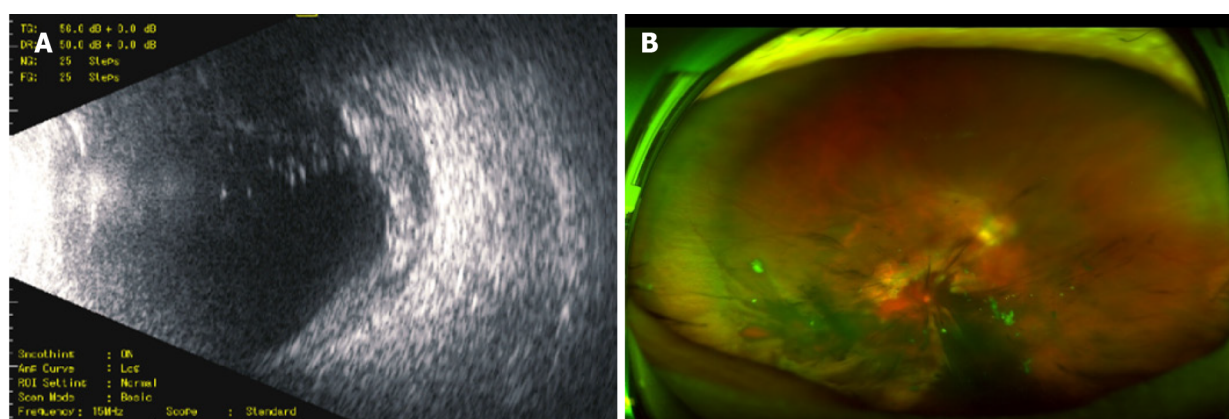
Ultrasound images. A: Ultrasound image of the fundus of the right eye after the first-stage scleral suturing showing opacity of the vitreous body in the right eye, with an abnormal echo of eyeball wall; B: Opel fundus image showing the vitreous hemorrhage with clots in the anterior retina of the posterior pole.
